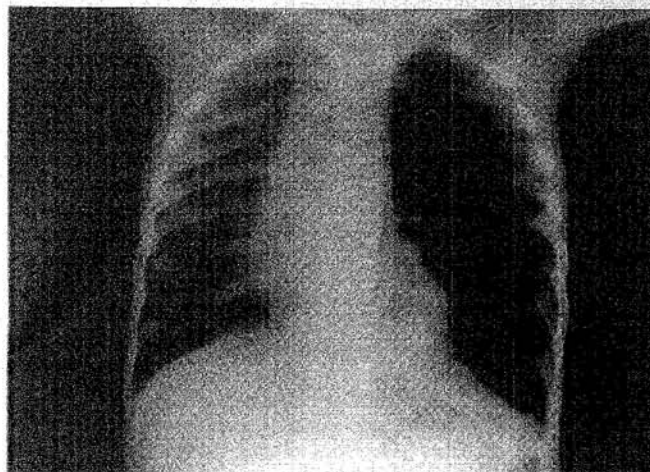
Left lateral decubitus chest x-ray of Case 1 showing the sign of air-trapping of left side more apparently
